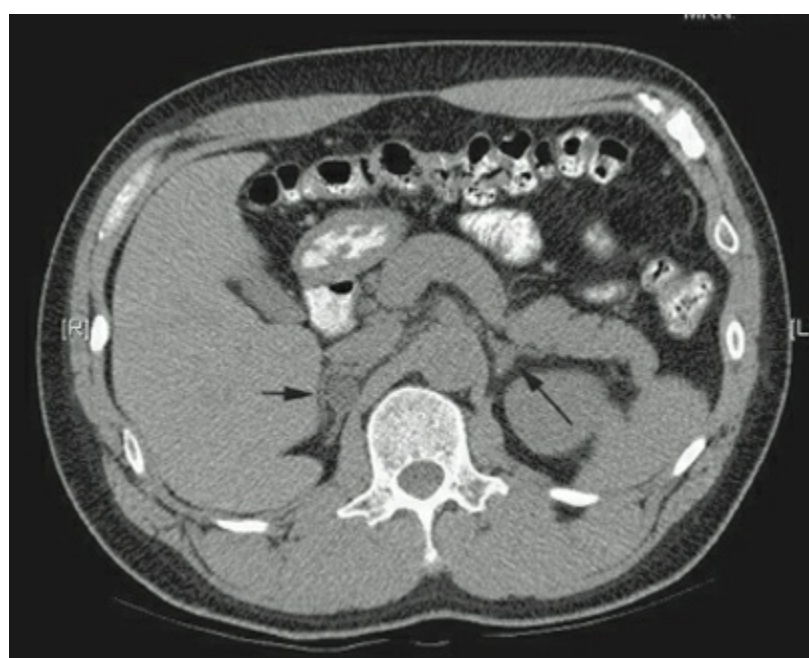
Computed tomography scan of right adrenal aldosteronoma. *Short arrow* shows aldosteronoma. *Long arrow* shows normal contralateral adrenal gland.
